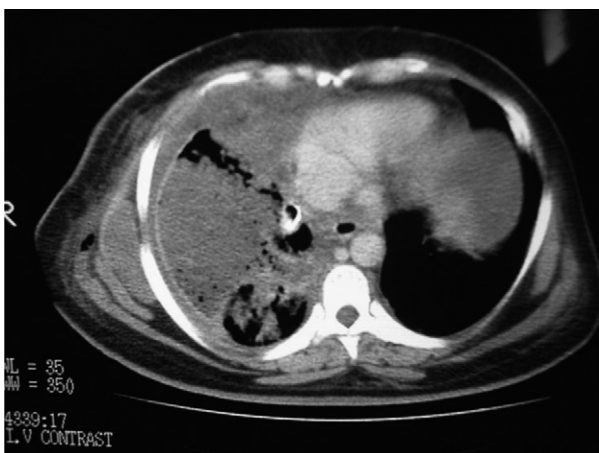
Thorax computed tomography scan showing cystic vesicles in the pleural cavity as well as a hydatid cyst in the serratus muscle anterior.
